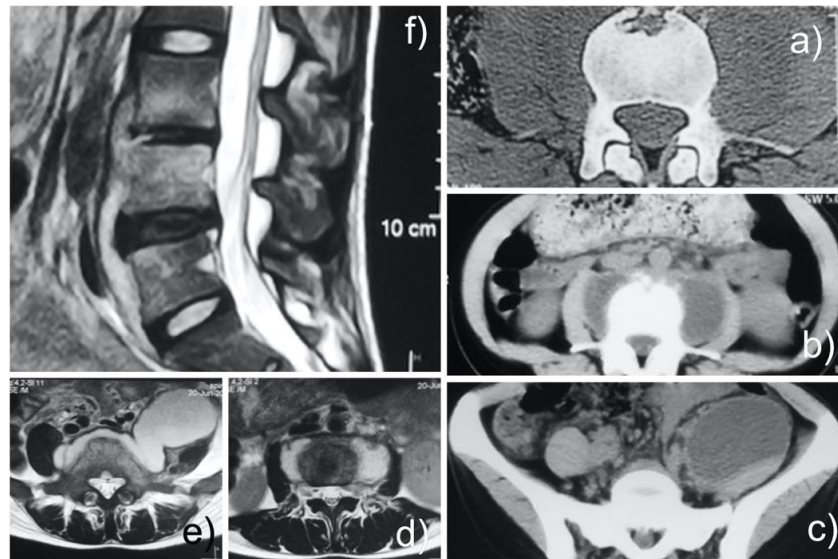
The preoperative CT examination showed that the psoas major muscle was infected, and the vertebral bone was destroyed. Further investigation of preoperative MRI showed that the intervertebral space collapsed, the vertebral body destruction was relatively light, and the paravertebral infection abscess was huge.
